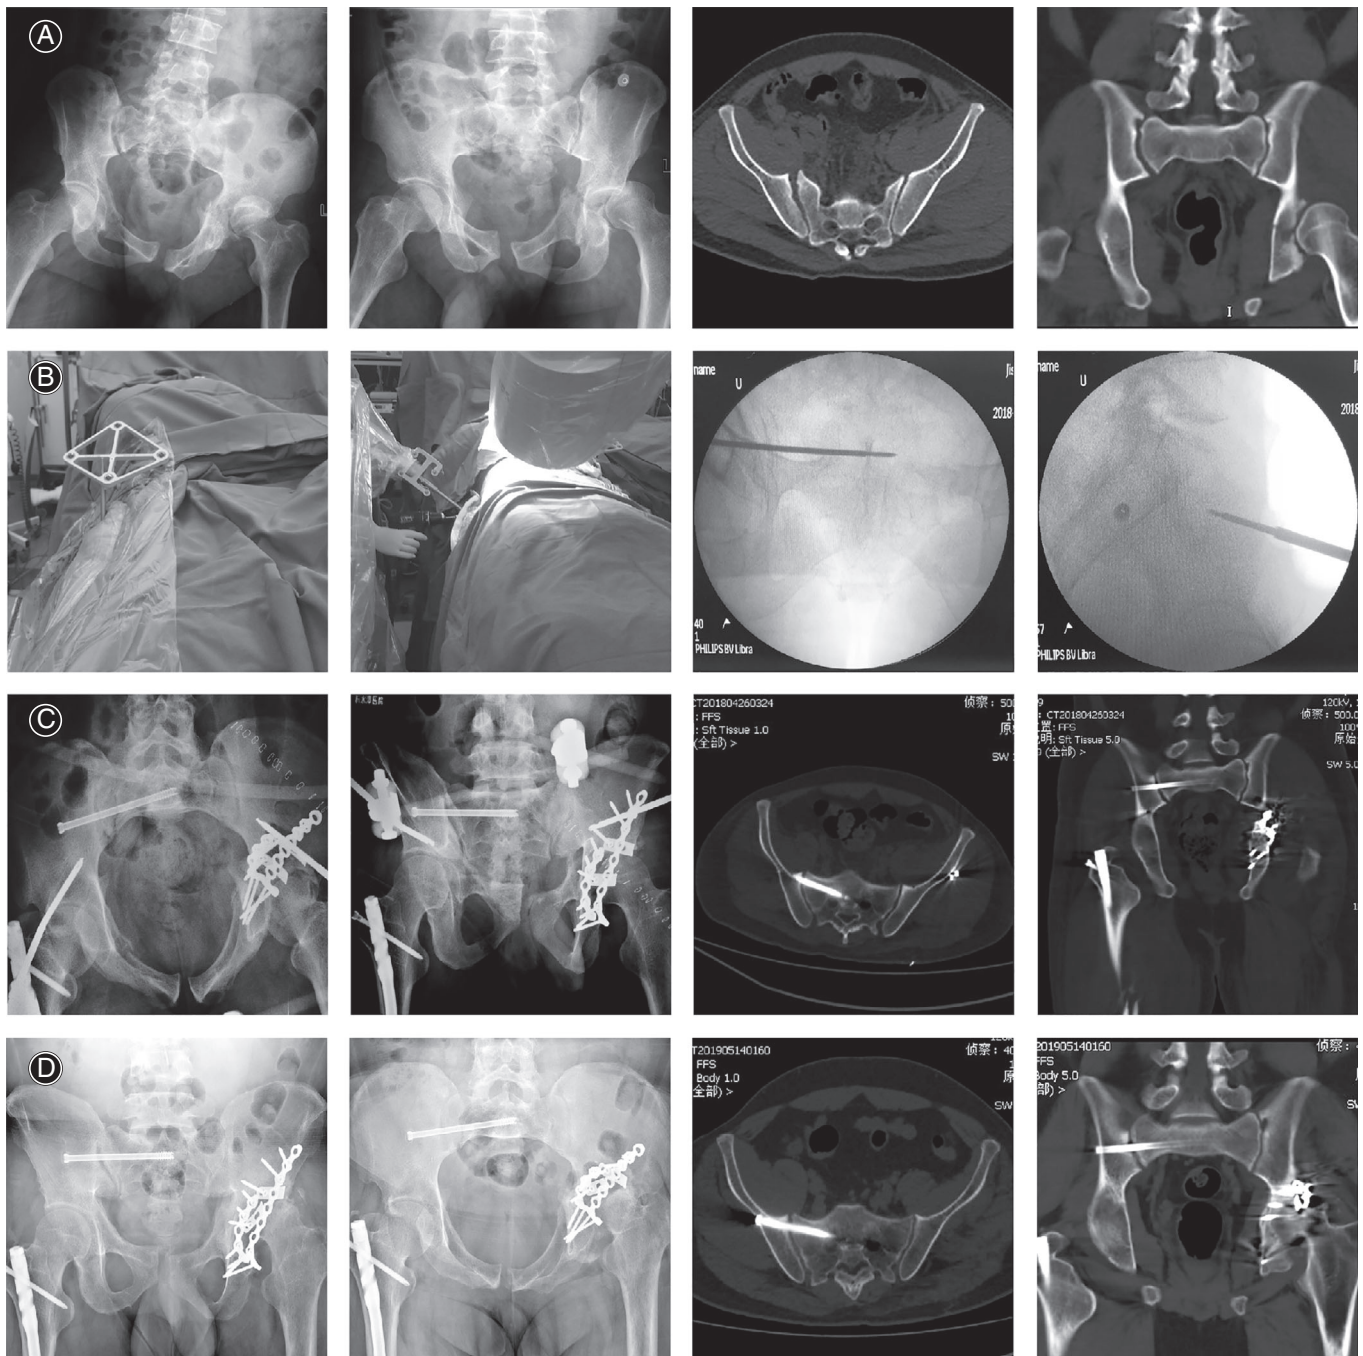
A series of images of typical case. Preoperative X-ray and CT scan (A); intraoperative images (B); postoperative X-ray and CT scan (C); and 1-year follow-up X-ray and CT scan (D).
